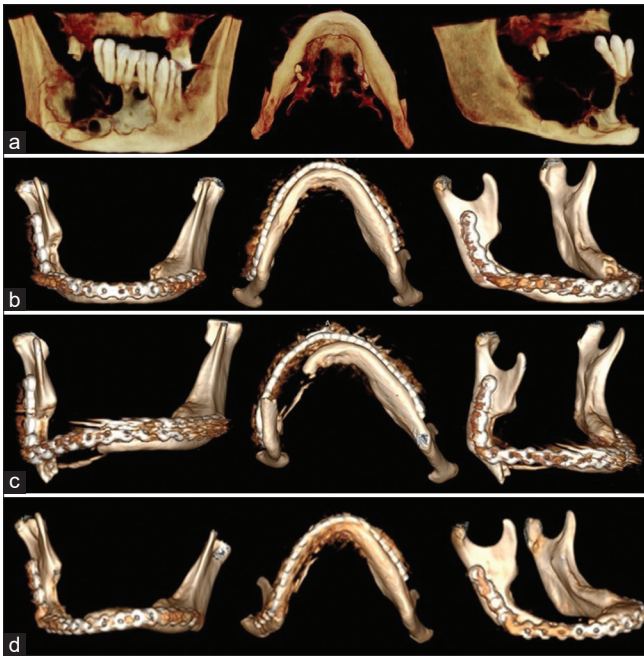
(a) Three-dimensional view from first computed tomography scan (b) Postoperative three-dimensional view of mandibular marginal resection (c) Three-dimensional view from first computed tomography scan of facial trauma (d) Postoperative three-dimensional view of mandibular osteosynthesis
